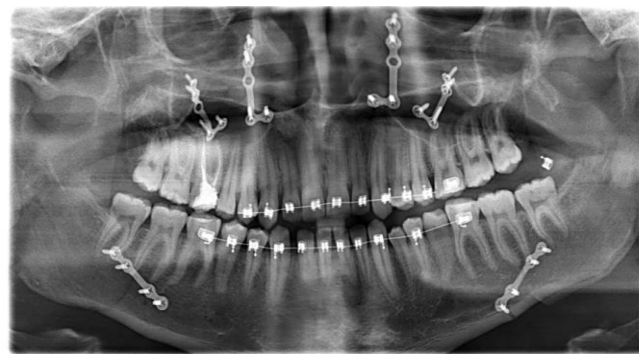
Postoperative panoramic radiograph (low medial cut).
